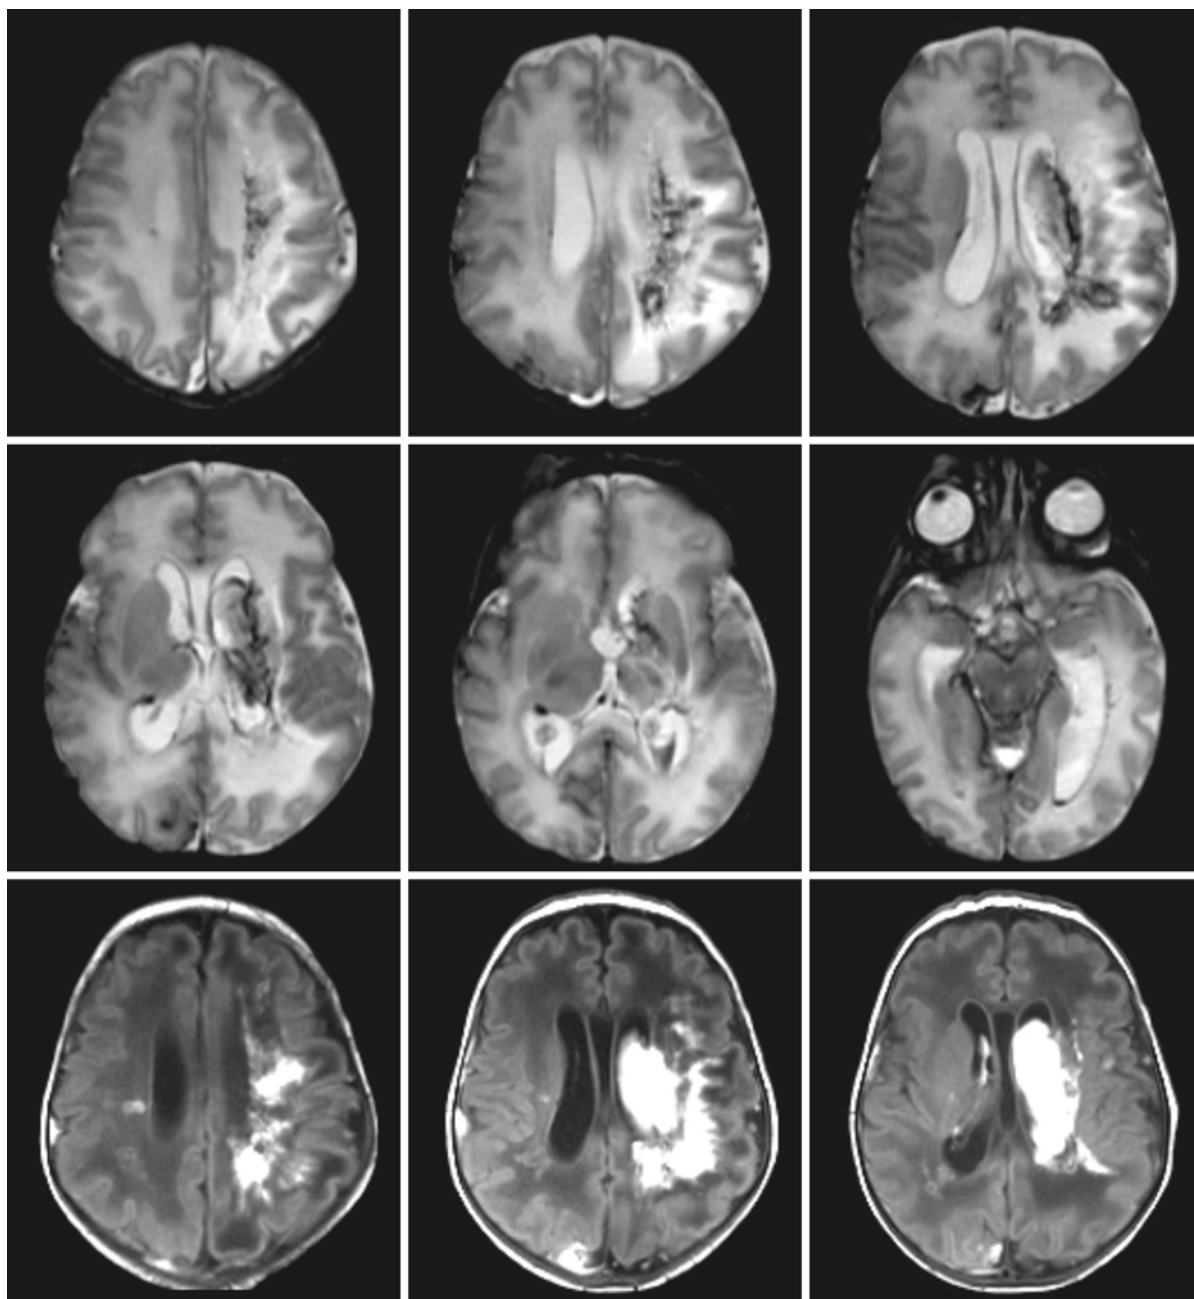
a Boy born at 38 weeks of gestation. The pregnancy was complicated by hypertension and perinatal asphyxia occurred. MRI at the age of 1 week showed mildly dilated lateral ventricles. T₂-weighted (*first and second rows*) and T₁-weighted
